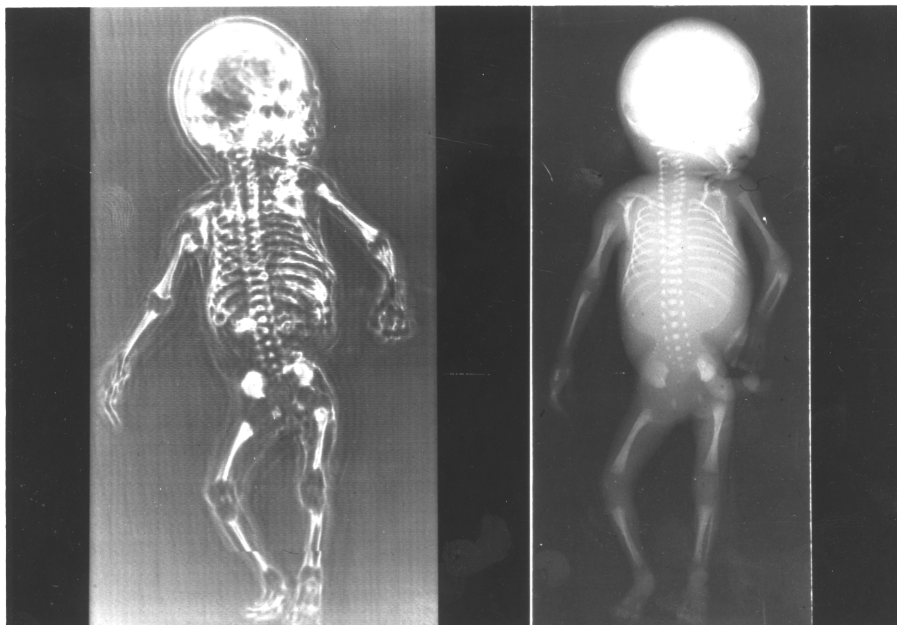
The (left) ultrasound and X-ray images of an ex vivo human fetus. The detail of the ultrasound image was unprecedented and markedly raised the awareness of what diagnostic ultrasound could do.
